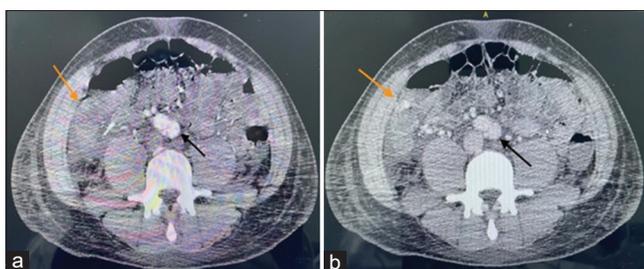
(a) Multiphase CT scan in the arterial phase with hyperdense contrast in the bilateral iliac arteries (black arrow). There is no hyperdensity in the cecum on the arterial phase (orange arrow). (b) CT scan in the delayed phase venous showing less dense contrast in the arteries (black arrow). There is new hyperdense contrast material within the cecum (orange arrow). This was not previously seen in the arterial phase and represents active extravasation into the cecal lumen.
